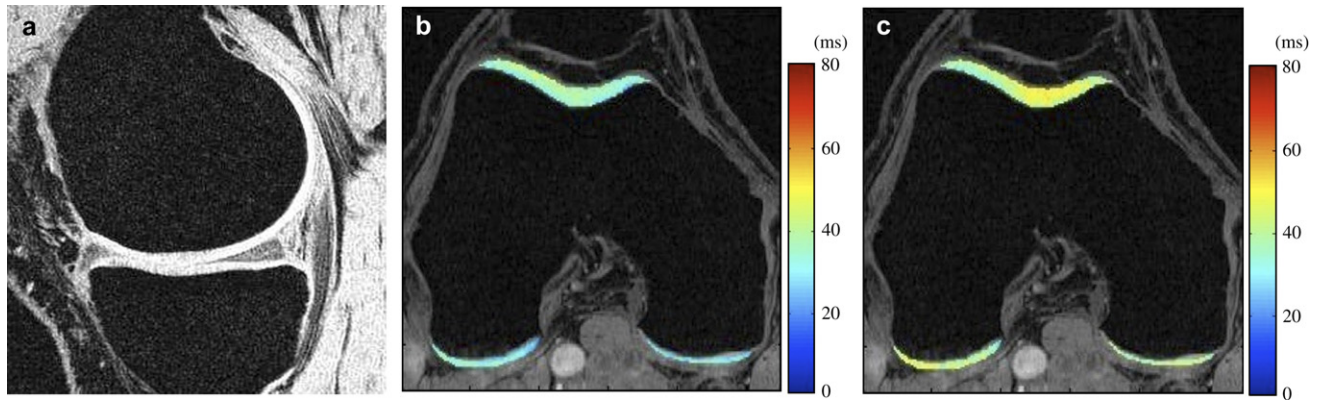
T_1 -weighted water excitation SPGR image (a), $T_{1\rho}$ map (b) and T_2 map (c) for a healthy control (male, 30). No radiographs were obtained, as the subject is a healthy asymptomatic control. No cartilage thinning, osteophytes and other OA symptoms were seen in MR images. The average $T_{1\rho}$ value was 40.1 ± 11.4 ms and the average T_2 value was 33.3 ± 10.5 ms in cartilage.
